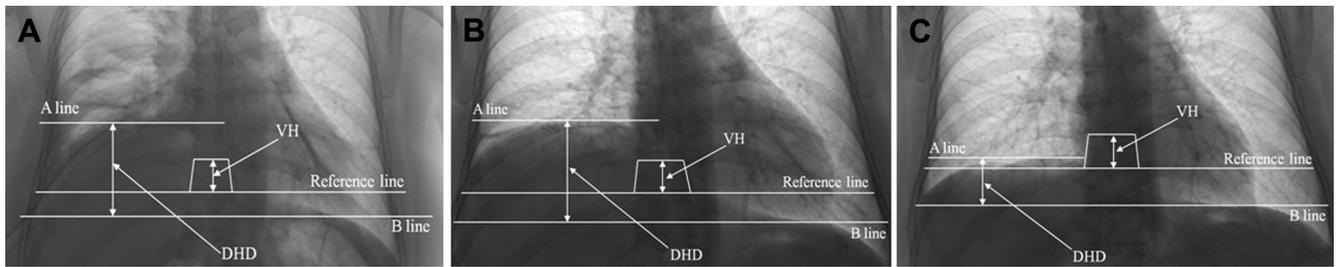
Posteroanterior chest radiograph. Diaphragmatic height index (DHI) = diaphragmatic height difference (DHD)/vertebral height (VH). Upon the initial chest radiograph (A), DHD = 60.30, VH = 22.3, and DHI = 2.7. At the time of rehabilitation evaluation (B), DHD = 49.55, VH = 20.81, and DHI = 2.4. After treatment (C), DHD = 32.45, VH = 21.52, and DHI = 1.5.
